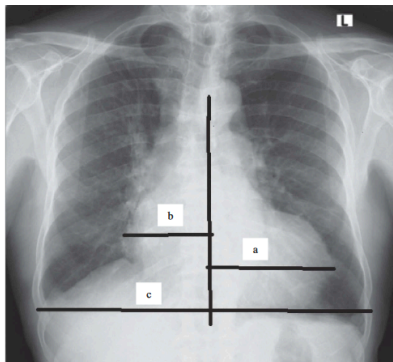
PA chest x-ray showing CTR (a = the distance from the right heart border to the midline, b = the distance from the left heart border to the midline, and c = the maximum thoracic diameter) (Alghamdi et al., 2020)
